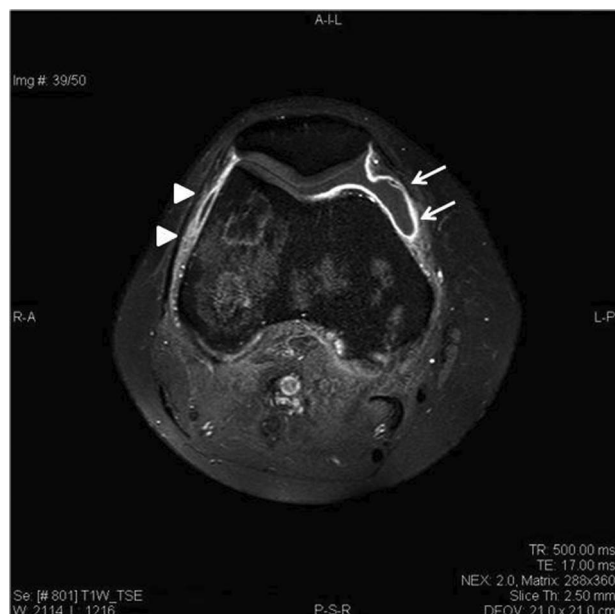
Magnetic resonance imaging (MRI) of right knee at onset of arthritis. MRI (contrast-enhanced T1W fat-suppressed spin-echo image) of the right knee showing extensive effusive synovitis involving the tibiofemoral joint space (arrows) as well as synovial thickening (arrowheads).
